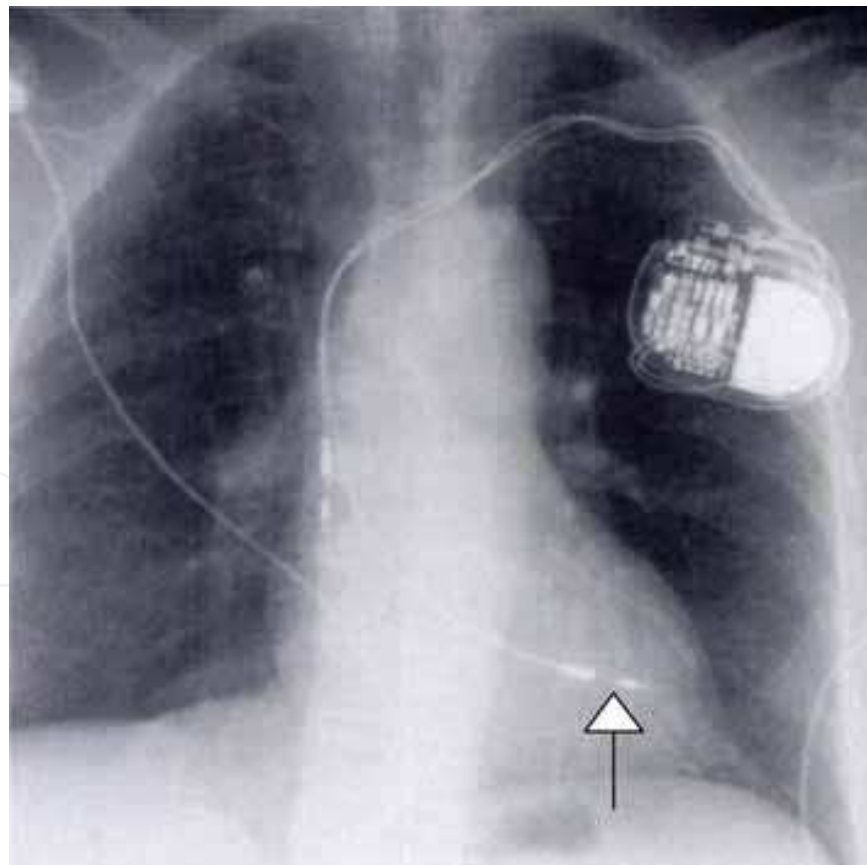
Chest radiograph obtained after pacemaker implantation shows that ventricular lead is displaced superiorly in left ventricle
